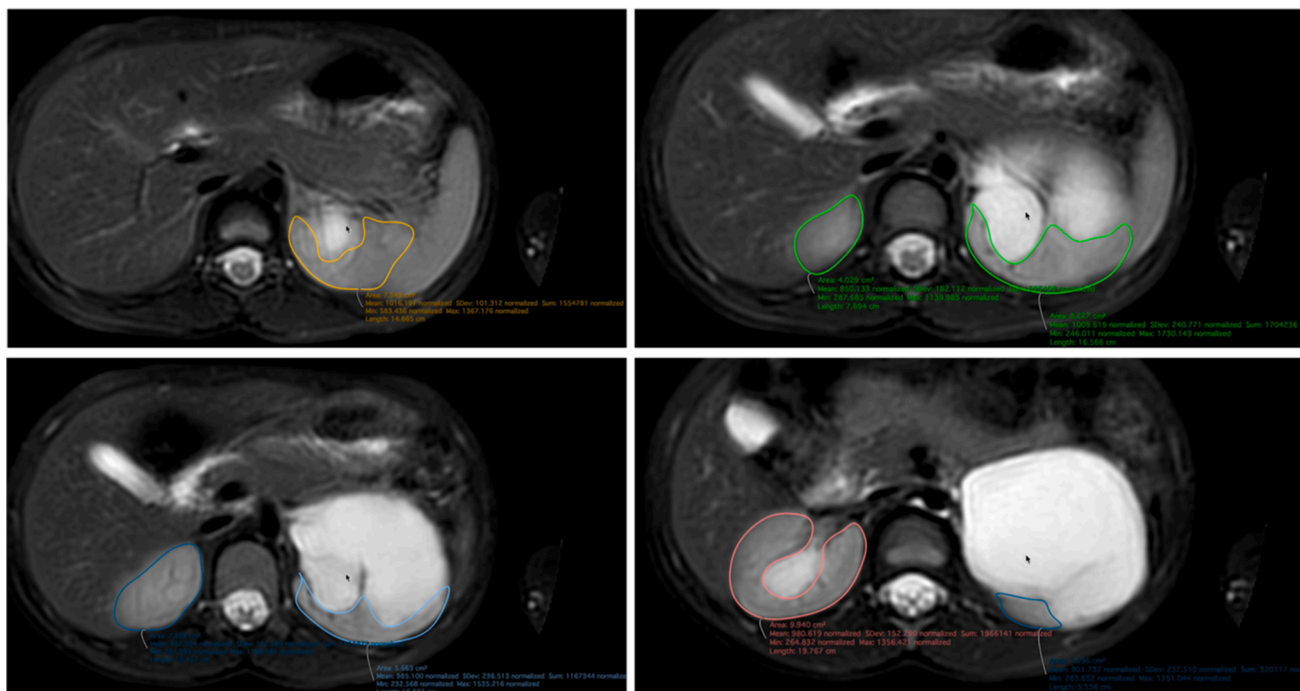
Axial T2-weighted non-contrast-enhanced magnetic resonance urography (NCE-MRU) images showing manual polygon-based segmentation of renal parenchyma for volumetric analysis in a child with left ureteropelvic junction obstruction (UPJO). Slice-wise regions of interest exclude the pelvicalyceal system and renal sinus, enabling calculation of cumulative renal parenchymal volume and split renal volume.
